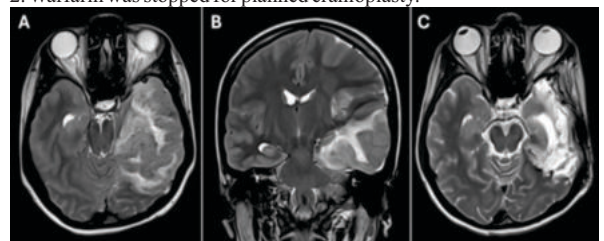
showing the T2 weighted magnetic resonance images of the patient. Axial (A) and coronal (B) were obtained at admission demonstrating the large left temporal and parietal haemorrhagic infarction with midline shift, medial temporal lobe herniating and compressing and markedly distorting the midbrain. Optic nerve is wavy tortuous and the perioptic cerebrospinal fluid space is enlarged.
